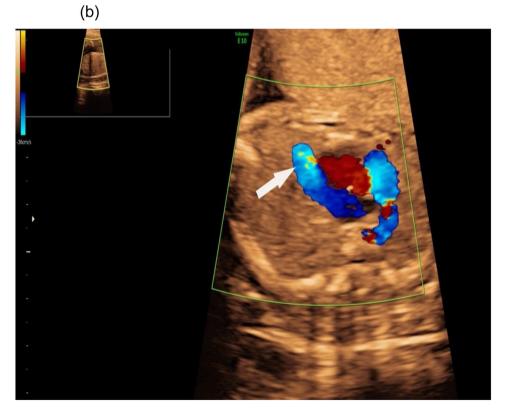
Ultrasound imaging of the fetal umbilical systemic shunt (a) Sagittal view of the umbilical vein running among the anterior surface of the liver. (b) Direct connection between umbilical vein and right atrium.
